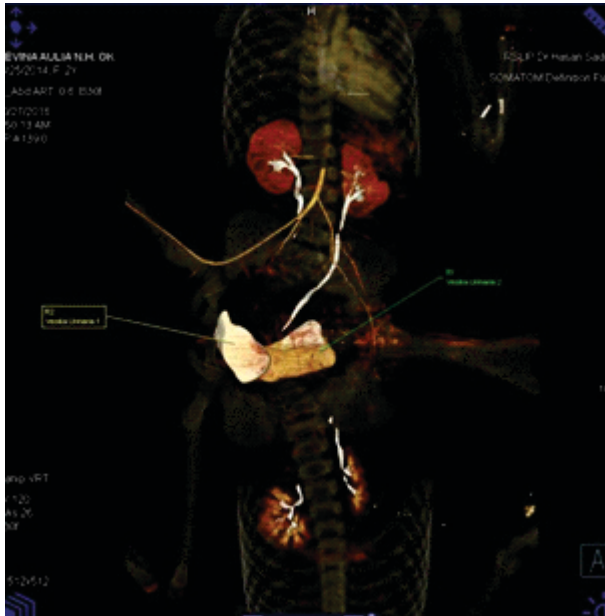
CT Angiography of genitourinary tracts.
